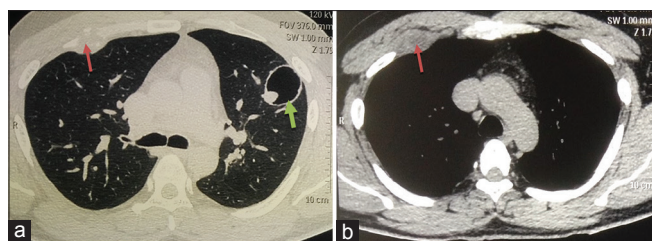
Contrast-enhanced computed tomography chest showing osteolytic lesion in right third rib (red arrow) and cavitary lesion with nodular component in left lung (green arrow)
